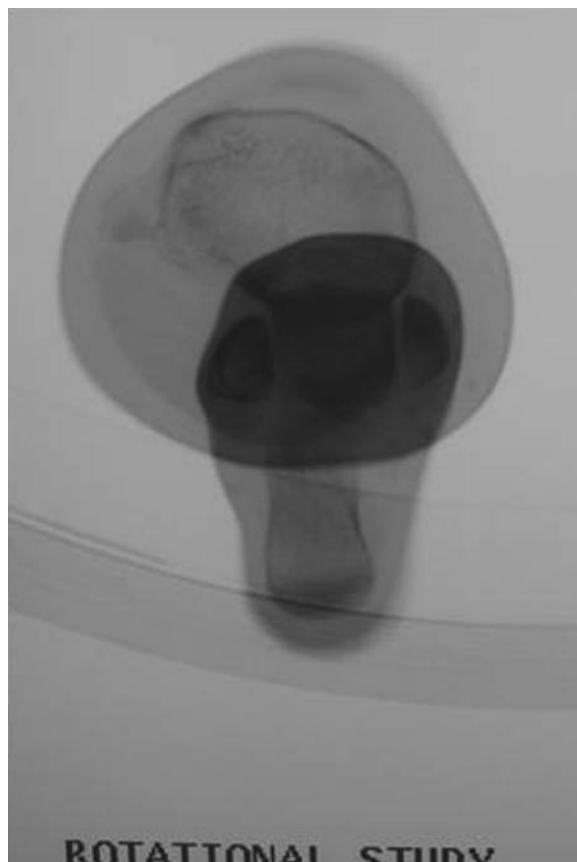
CT of the proximal tibia and distal tibia superimposed so the lines may be drawn to measure tibial torsion. Here the tibial torsion is 31°
